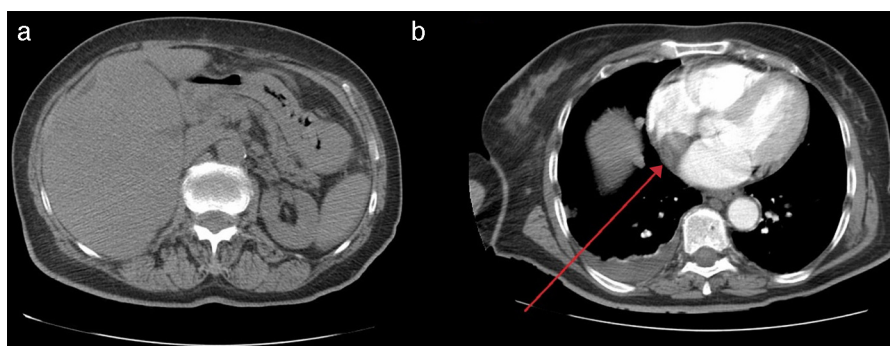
Total body computed tomography scan: (a) large metastatic mass in the right hepatic lobe; (b) thoracic level, the arrow indicating the RA filling defect.
